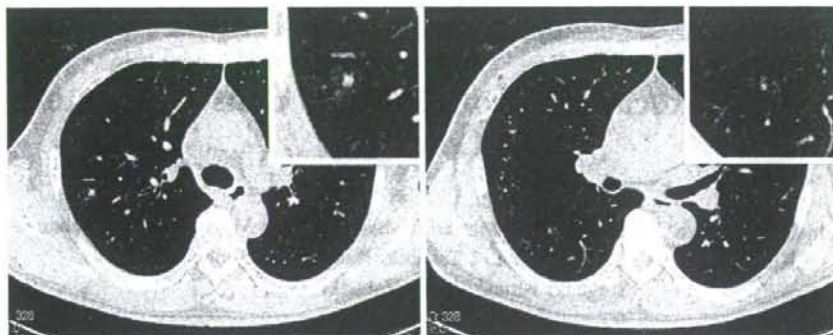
Chest CT scan image showing nodule with halo and ill-defined margin (left), and groundglass opacity with an ill-defined margin (right). The lesion is shown magnified in the inset.
